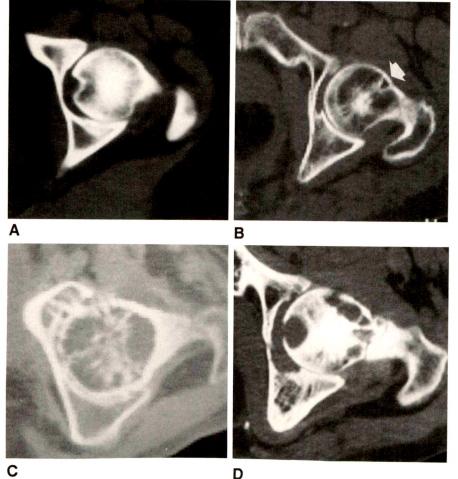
Various manifestations of "asterisk" sign. Transverse CT scans with 6-mm sections through femoral head.
